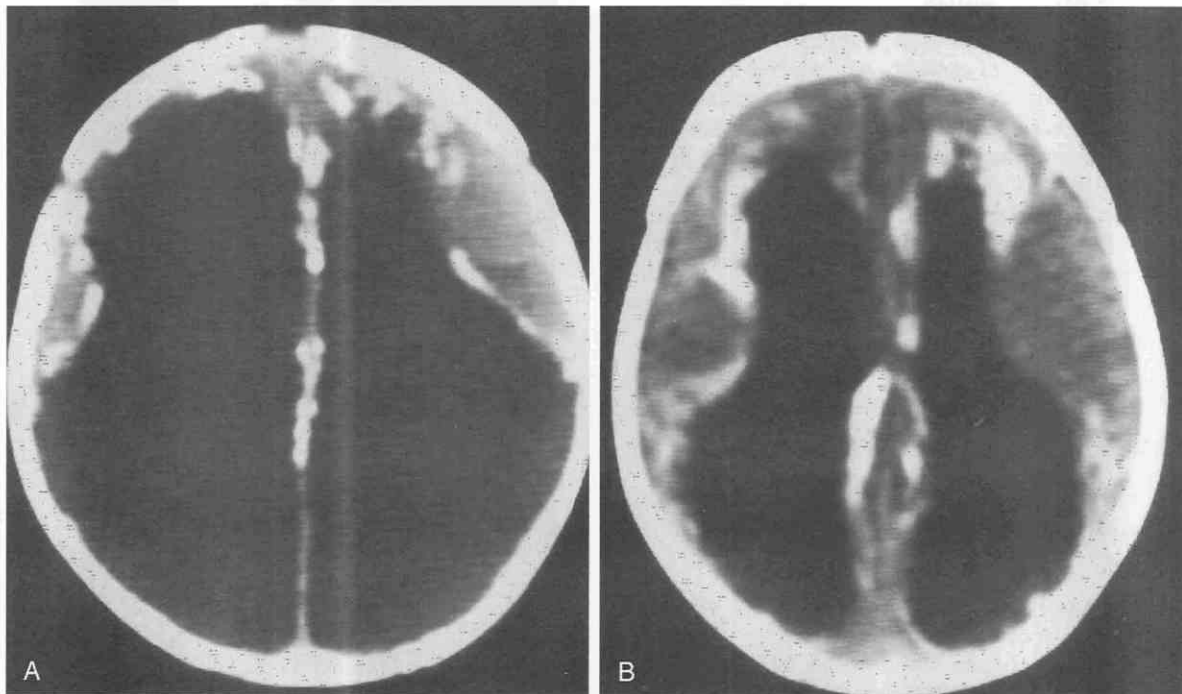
A and B, Cytomegalic inclusion disease. Unenhanced CT scan in a newborn shows periventricular calcification and ventricular dilatation.
